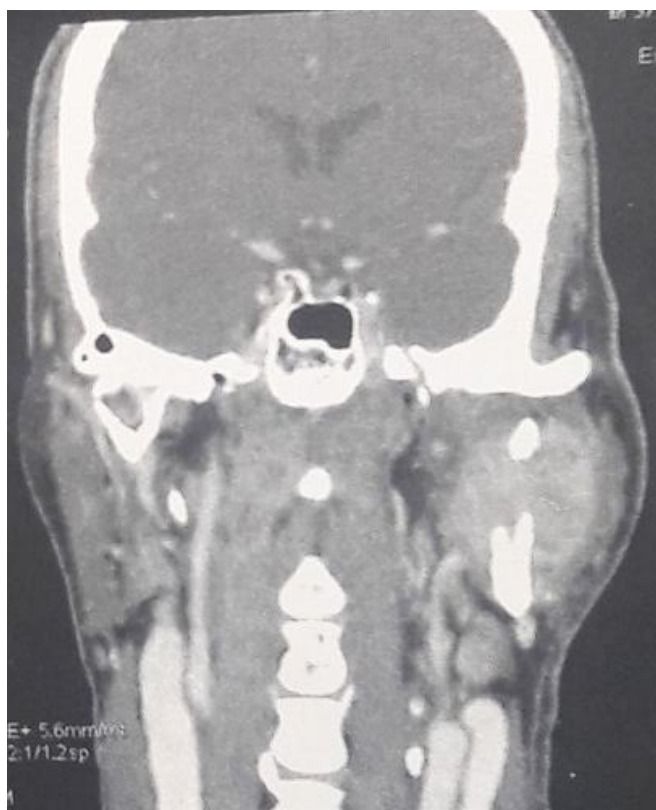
coronal computed tomographic view (soft tissue window) showing a lump surrounding the left ramus with irregular bone destruction and muscle infiltration
